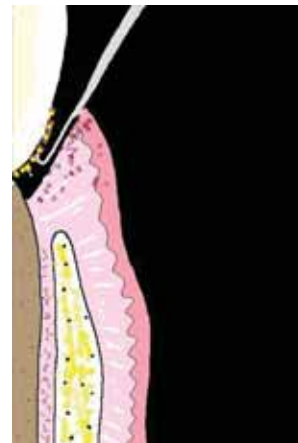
Ultrasonic and manual scalars used for subgingival scaling and root planing
